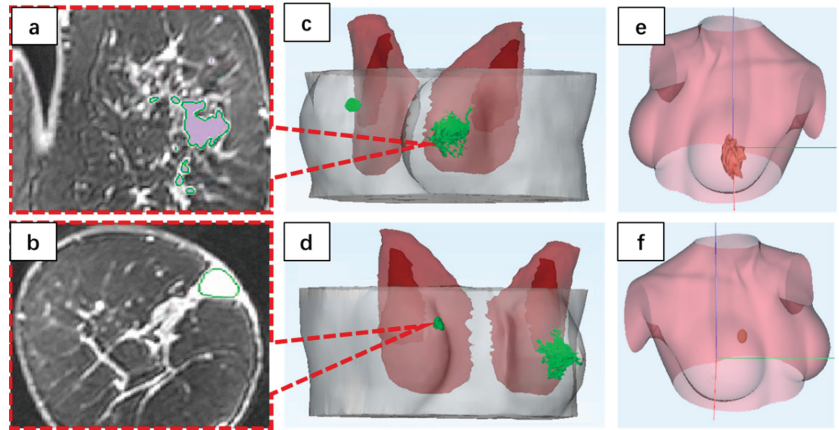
Result of Subject 1. (a,b) Representation of the MRI imaging parts of the left and right breast of Subject 1. (c,d) Reconstruction structure based on the MRI. (e,f) Generative models of 3D-based breast ultrasound system.
